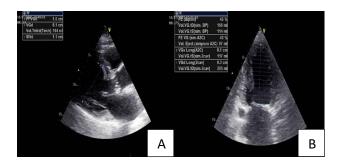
(A and B): Transthoracic echocardiogram showing a dilated left ventricle with reduced ejection fraction.
